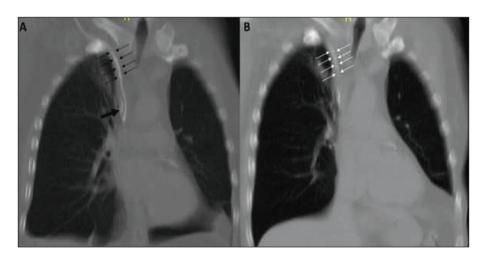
A) Pre-removal chest CT image depicting a port catheter already accompanied by a certain degree of calcification at the distal end (thick arrow), along with coarse, irregular hyperdensities that are consistent with the calcifications, encasing the proximal portion of the catheter (thin arrows). B) Post-removal chest CT image depicts peri-catheter fibrin sheath cast mimicking a retained catheter fragment (arrows). CT: Computed tomography.
